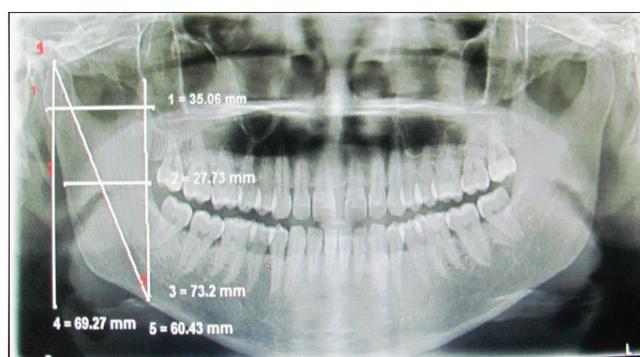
Mandibular ramus measurements of female patient on orthopantomograph
